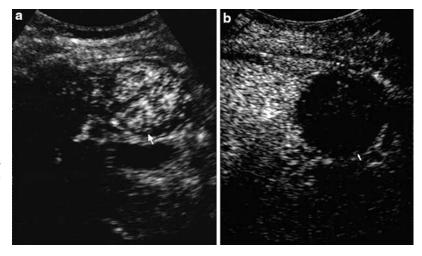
Contrastenhanced ultrasound images in a patient who underwent combined PEI-RF ablation of HCC. (a) Arterial phase image shows a subcapsular 3.8×4.5 -cm tumor (*arrow*). (b) Image obtained 1 month after the treatment shows a coagulation zone of 4.8×5.7 cm (*arrow*)
